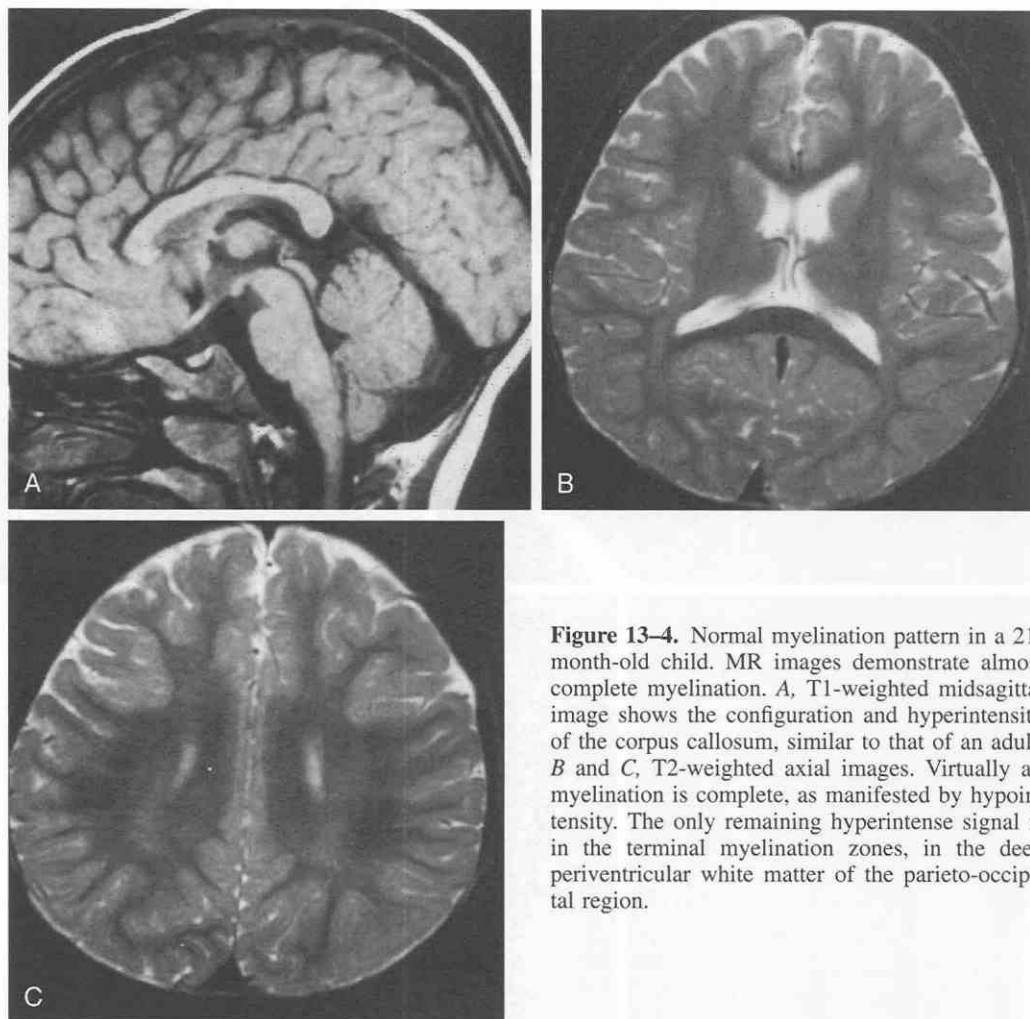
Normal myelination pattern in a 21-month-old child. MR images demonstrate almost complete myelination. A, T1-weighted midsagittal image shows the configuration and hyperintensity of the corpus callosum, similar to that of an adult. B and C, T2-weighted axial images. Virtually all myelination is complete, as manifested by hypointensity. The only remaining hyperintense signal is in the terminal myelination zones, in the deep periventricular white matter of the parieto-occipital region.
